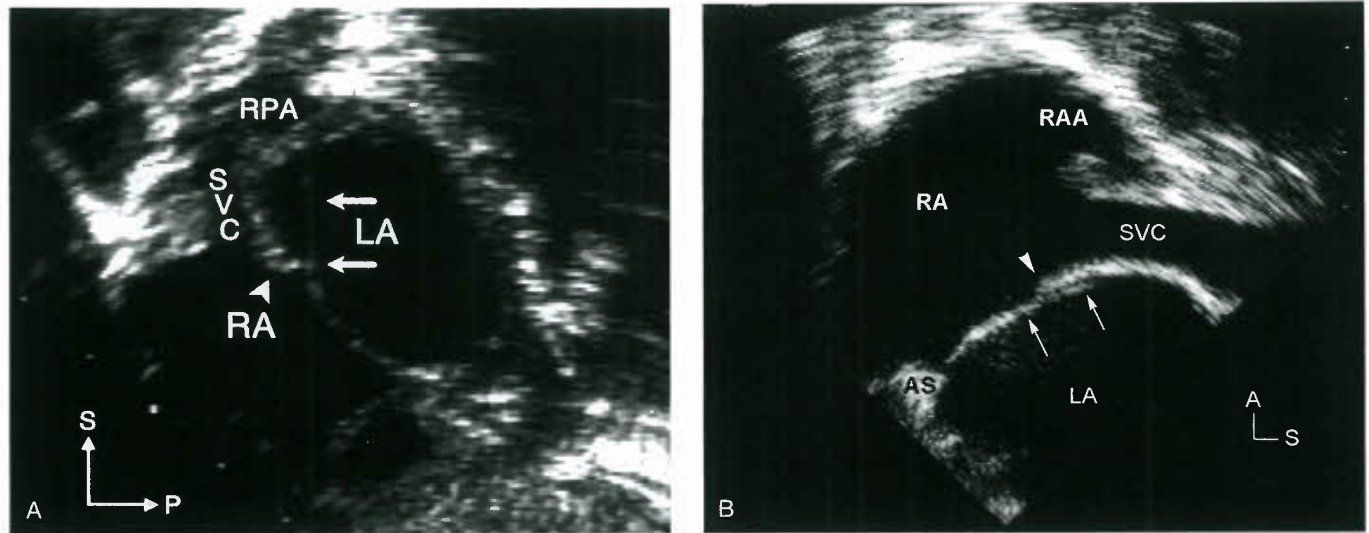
Atrial situs. A: Subcostal parasagittal view demonstrating the right and left atria in a newborn. The right atrial aspect, the limbus of the fossa ovalis (septum secundum) is identifiable (*arrowhead*), and on the left atrial side, the valve of the fossa ovalis (septum primum) is evident (*arrows*). B: Long-axis transesophageal scan of the atrial septum (AS) demonstrating similar anatomic landmarks to define atrial situs. Again the *arrowhead* points to the limbus of the fossa ovalis of the morphologic right atrium (RA). The *arrows* point to septum primum on the left. Note that the right atrial appendage (RAA) is observed anterior and adjacent to the superior vena cava (SVC). The RAA has a broad base and pyramidal shape. (A, anterior; LA, left atrium; P, posterior; RPA, right pulmonary artery; S, superior.)
